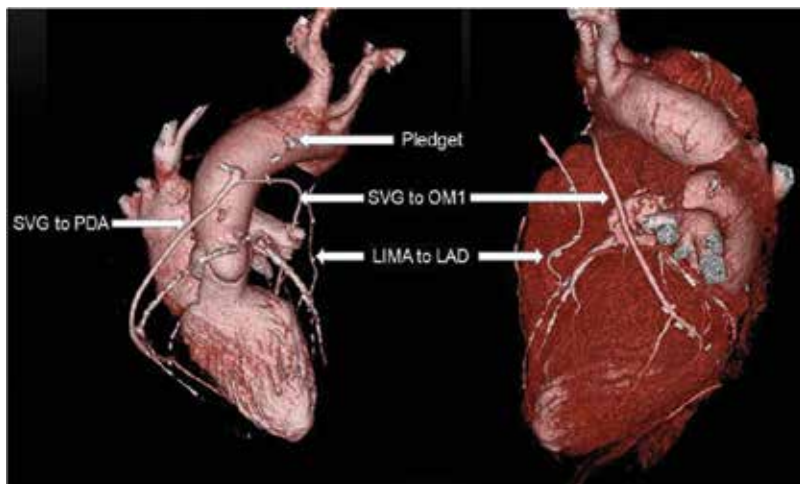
Volume-rendering reconstructed images of CTA of post-CABG showing the type and course of multiple different bypass grafts. The images show grafted saphenous vein graft (SVG) to posterior descending artery (PDA), left internal mammmary artery (LIMA) to left anterior descending artery (LAD), and SVG to first obtuse marginal (OM1) artery. The three grafts are patent, and the native coronary arteries show different grades of stenosis. A high-attenuation felt pledget is depicted at the distal portion of the ascending aorta. Note that the high-attenuation focus is located external to the aortic wall.
